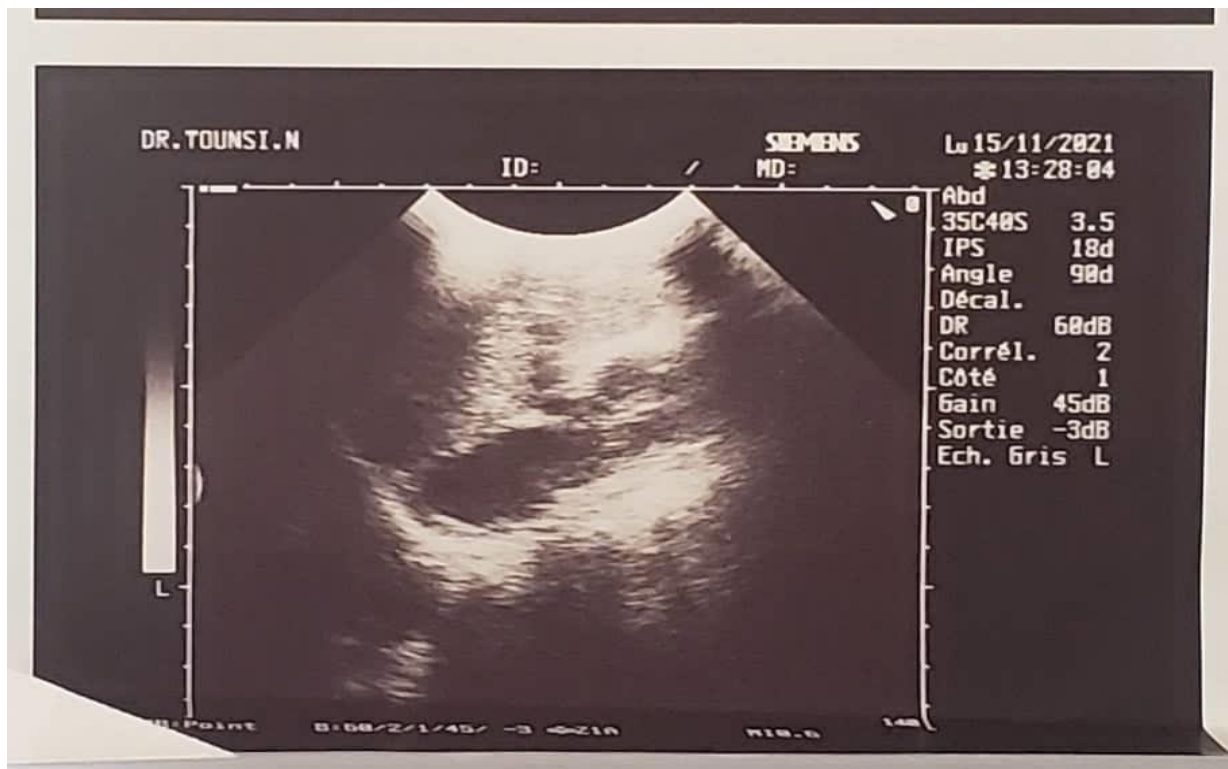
Ultrasound showing ureteral dilation in a patient in our series.
